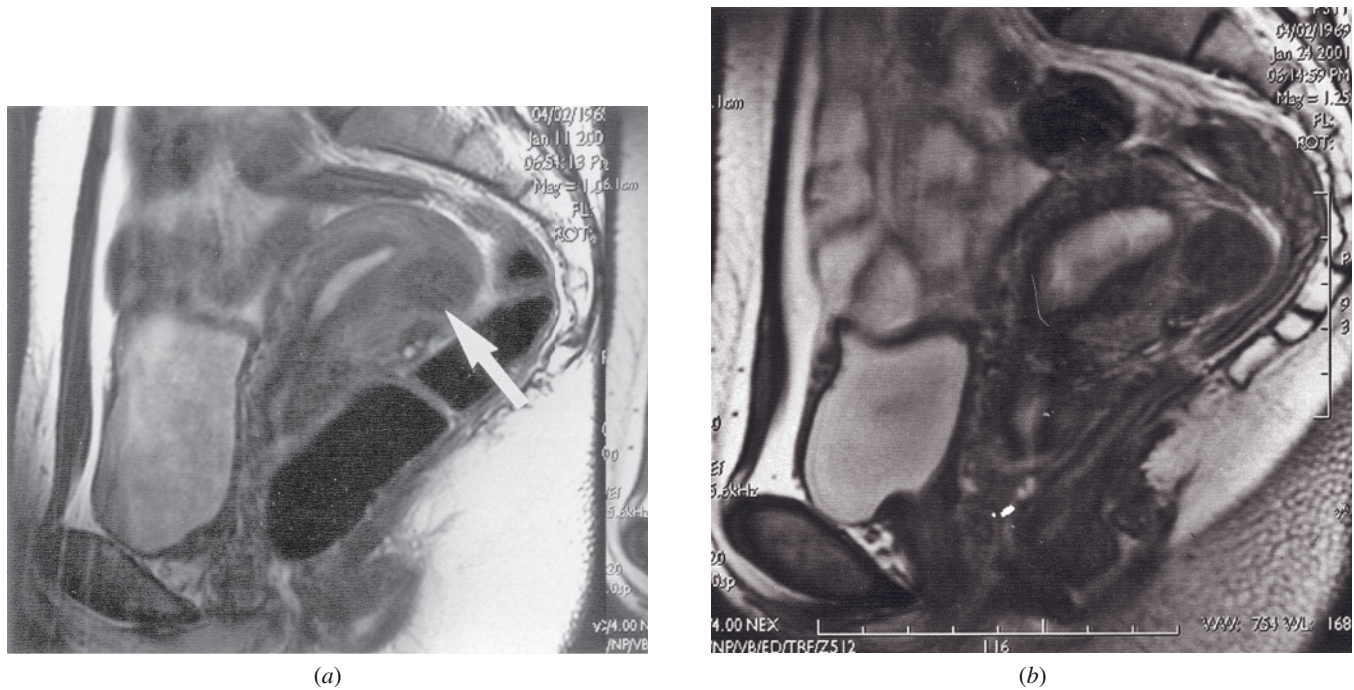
Physiological changes during menstrual cycle in a 32-year-old woman. Sagittal T2-weighted ETSE images at different phases of the menstrual cycle. A retroverted uterus with a small hypointense intramural leiomyoma (arrow, *a*) is apparent. During the follicular phase (day 5) (*a*), the hyperintense endometrial stripe is thin. During the secretory phase (day 18) (*b*), the endometrial stripe widens considerably, and the endometrial complex and myometrium show increased signal intensity.
